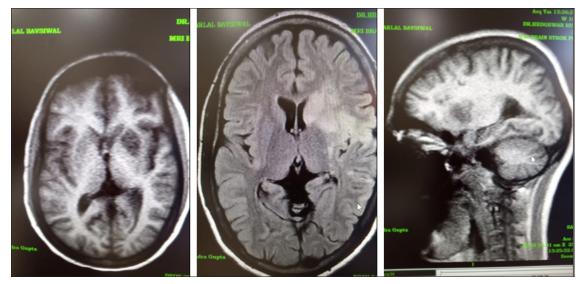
MRI images suggestive of Infarct
